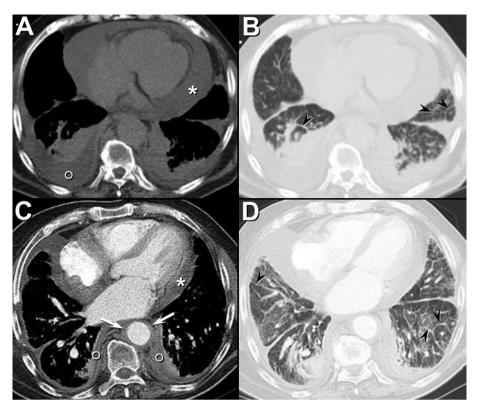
Unenhanced thoracic CT prior to therapy initiation displayed in soft tissue (A) and lung (B) windows shows bilateral pleural effusions (O), a moderate-sized pericardial effusion (*), and basal interlobular septal thickening (arrowheads). Enhanced thoracic CT displayed in soft tissue (C and lung (D) windows, performed approximately one year following initiation of corticosteroid therapy, shows reduction in bilateral pleural effusions (O) and pericardial effusion (*), but with increasing interlobular septal thickening (arrowheads). Perivascular soft tissue infiltration surrounding the descending thoracic aorta (arrows) is evident.
